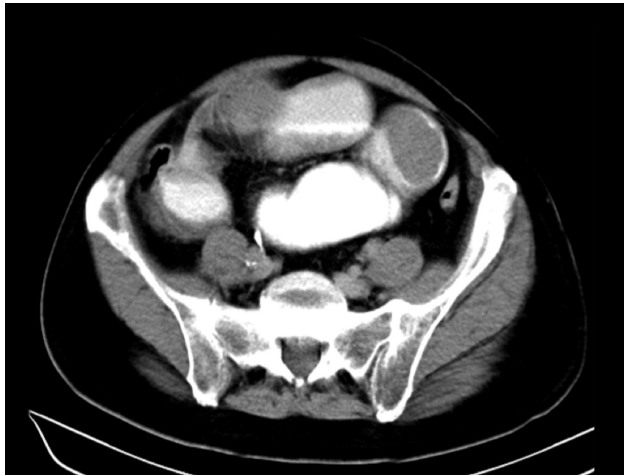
CT images of intestinal invagination: mass lesion in dilated jejunal loop segment.
